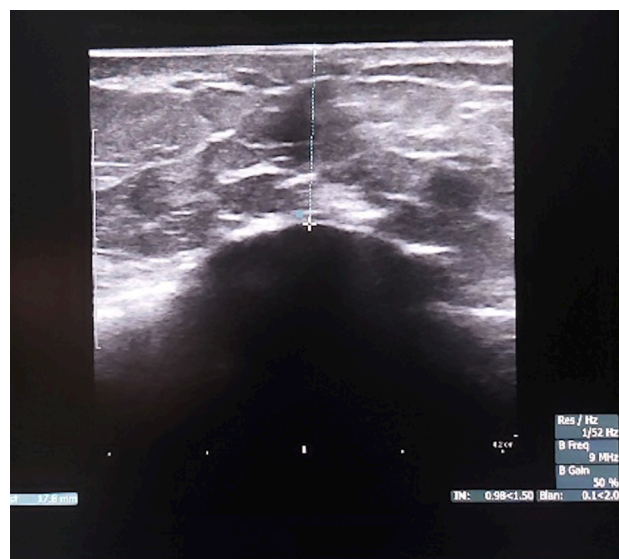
Measurement of the distance to the skin from the applicator with ultrasound image.
